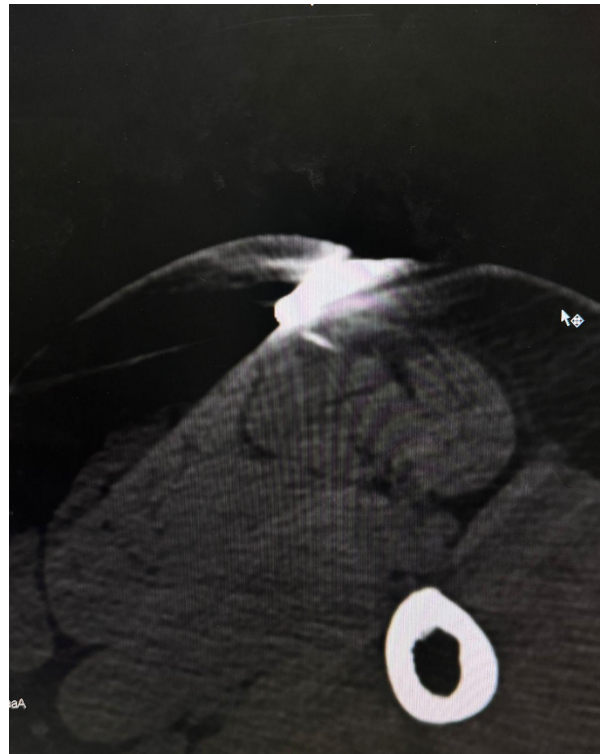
CT-guided intervention: Intra-procedural image demonstrating the needle and forceps positioned adjacent to the targeted foreign body for minimally invasive retrieval.
